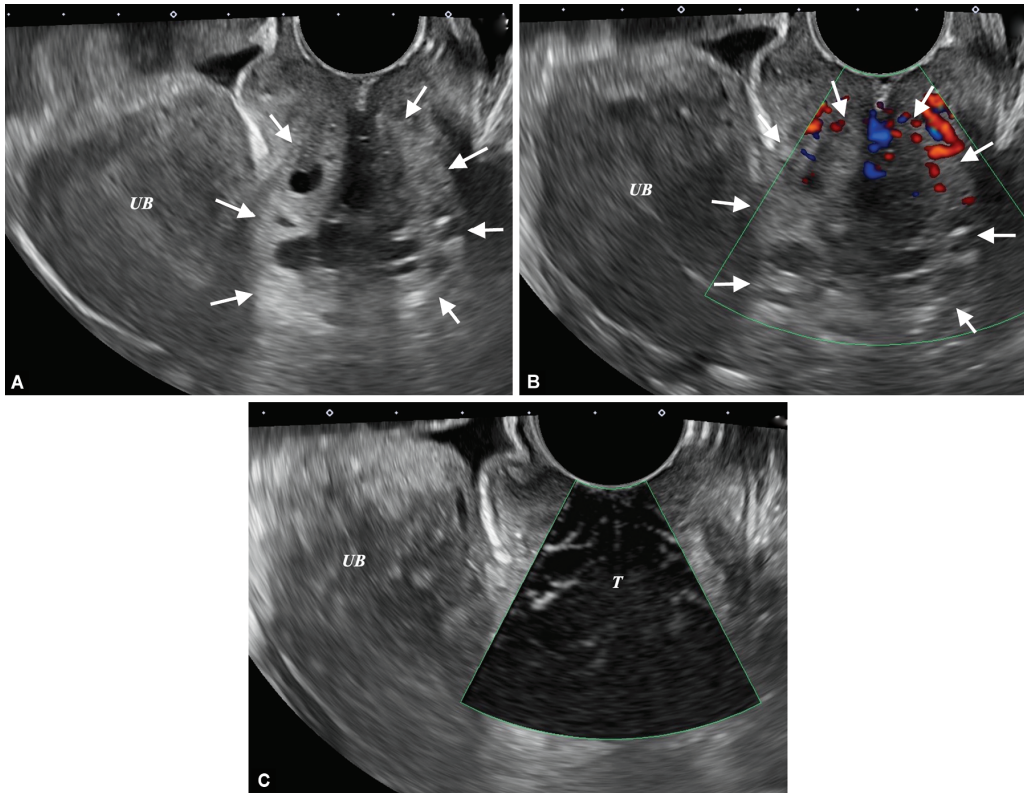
to C: Sagittal view of the uterus with missed abortion (arrow). Tiny blood vessels can be clearly identified in the contents of the uterine cavity by superb microvascular imaging (SMI), whereas conventional color Doppler only shows blood vessel buds at the base of the endometrium. (A) Two-dimensional sonography; (B) Color Doppler; (C) SMI
